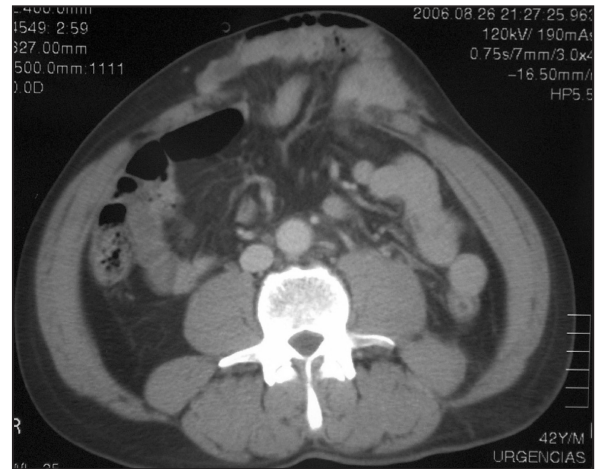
CT scan image showing a large orifice in the anterior abdominal wall through which small intestine loops emerge. A thin layer of skin contains the evisceration.
